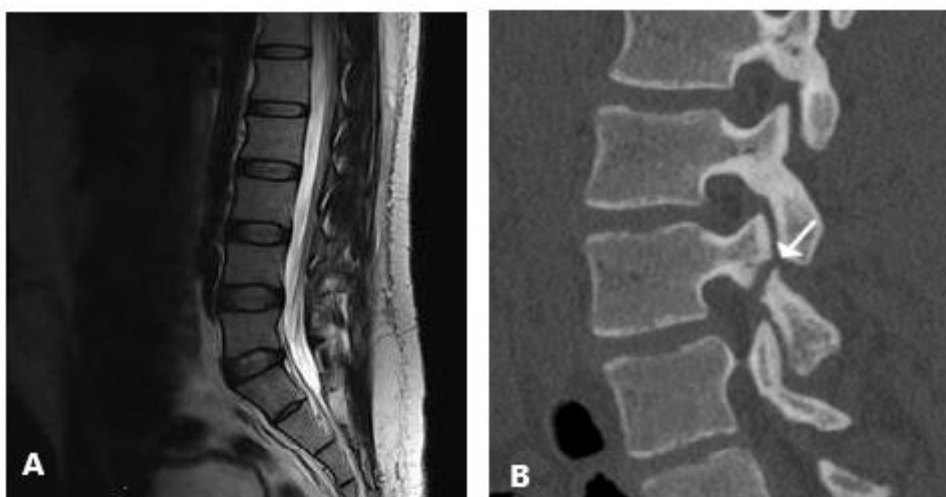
MRI scan (A) and CT scan (B) of the lower dorsal lumbar spine.
